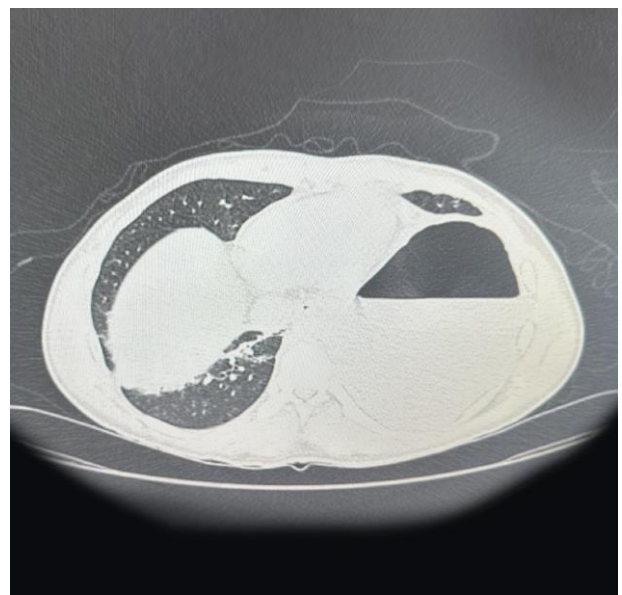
CT thorax demonstrating a large cystic lesion with an air-fluid level.
